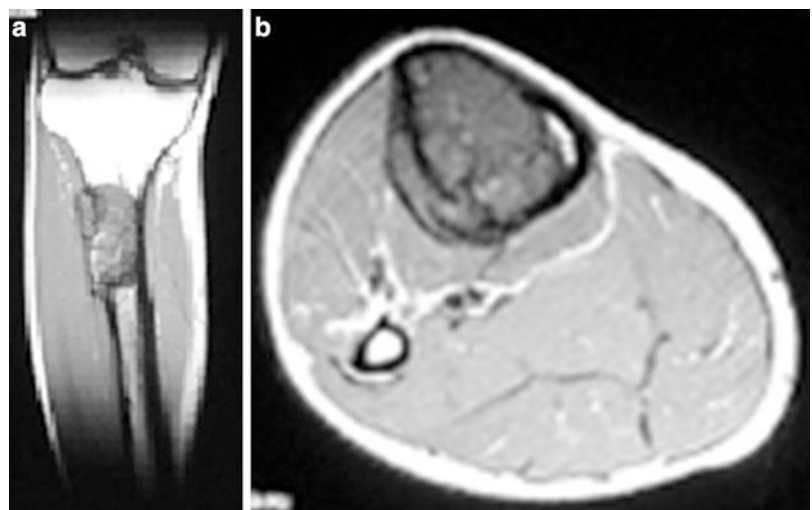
Post-chemotherapy MRI
